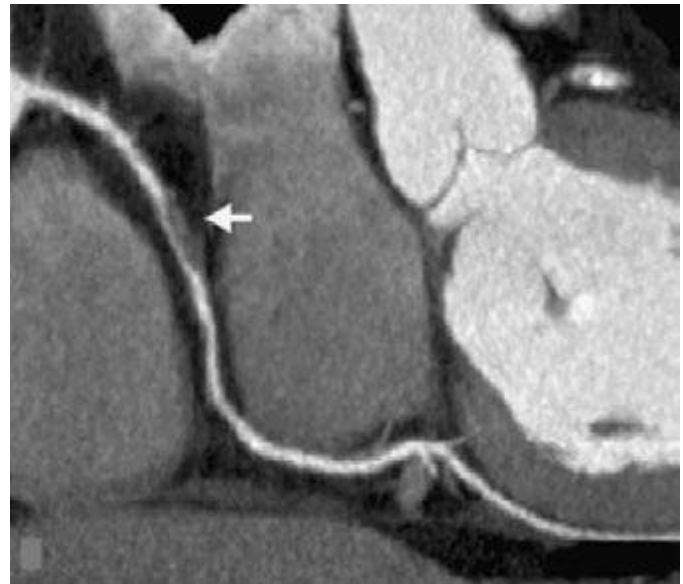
Coronary computed tomographic angiogram showing an obstructive plaque in the right coronary artery. (From PJ de Feyter, K Nieman. *Multislice computed tomography in acute coronary syndromes*, in Theroux P [ed]: *Acute Coronary Syndromes*, 2nd ed. Philadelphia: Elsevier, 2011.)
